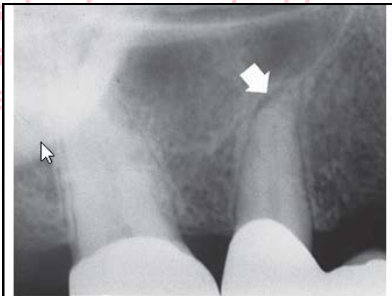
After cementing a three-unit bridge, the pre-molar developed clinical signs and symptoms of acute apical periodontitis, and the radiograph shows a widened periodontal ligament space (arrow).
